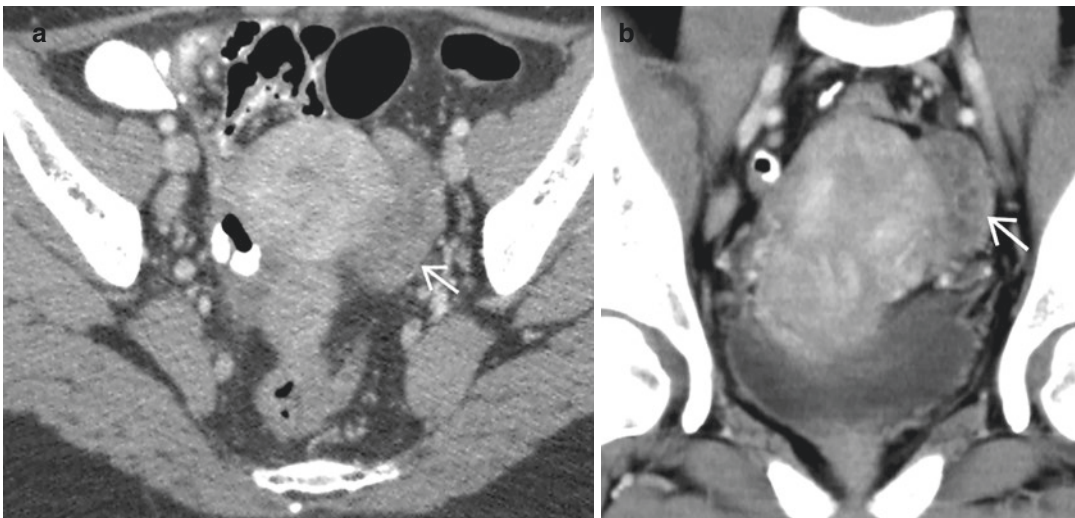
Left tuberculous salpingitis in a 34-year-old woman. (a) Axial and (b) coronal contrast-enhanced CT images show a fluid-filled dilated left fallopian tube or hydrosalpinx (arrow)
